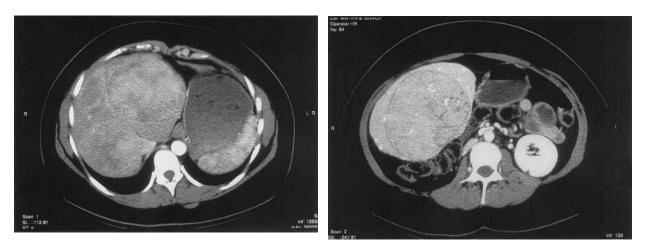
Arterial phase CT imaging of multiple FNH. Arterial phase images through the superior (A) and inferior (B) liver. A, There is a heterogeneous mass in the left lateral segment that is not hypervascular. The right lobe of the liver is atrophic. B, There is an exophytic mass projecting off of the medial segment of the left lobe, which is heterogeneous and contains multiple punctate calcifications.
